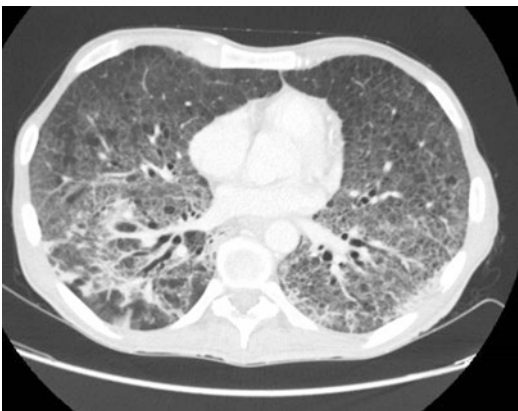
Chest computed tomography in an HIV-positive patient with pulmonary PCP
